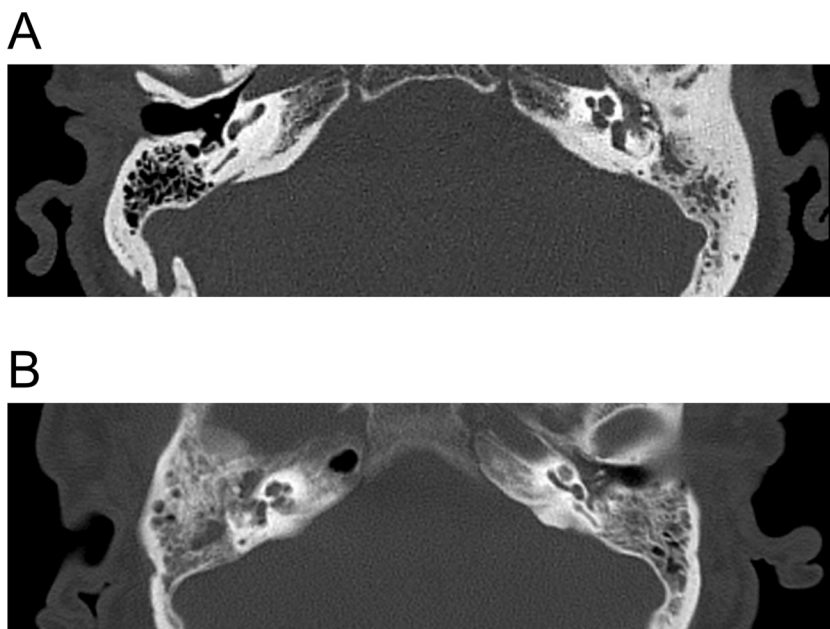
Representative CT images of a case and a control cohort patient. Axial unenhanced CT images show middle-ear cavity and mastoid region applying a bone kernel. A, image of a 73 years of age male patient suffering from acute mastoiditis. Mastoid and middle-ear cavity opacifications were scored as total (score: 4) and asymmetrical. Increased sclerosis is seen but no erosive or adjacent soft-tissue changes. B, image of an 80 years of age male patient suffering from delayed wake-up after arterio-coronary bypass procedure. The patient suffered from respiratory insufficiency, pneumonia and was resuscitated after cardiac arrest. Mastoid opacification was scored as asymmetrical and subtotal (score: 3), middle-ear cavity opacification was scored as total (score: 4) and symmetrical. There were no sclerotic, erosive or adjacent soft-tissue changes. There were no clinical signs of acute mastoiditis and opacification was interpreted as unspecific. The region of interest measurement of Hounsfield Units revealed a maximum and mean value of 1944 and 917 in A and 830 and 365 in B, respectively.
